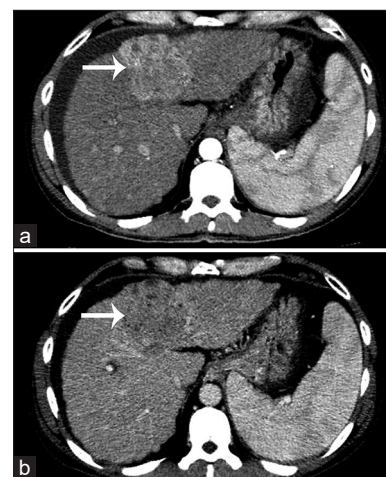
Computed tomography axial sections from arterial (a) and venous (b) phases. An ill-defined enhancing lesion in the liver on the arterial phase with washout on the venous phases, consistent with primary hepatocellular carcinoma (arrows).
